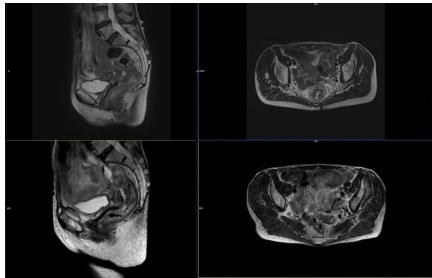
MRI of a patient with rectal cancer. SAgittal slides to the left and transaxial to the right.
